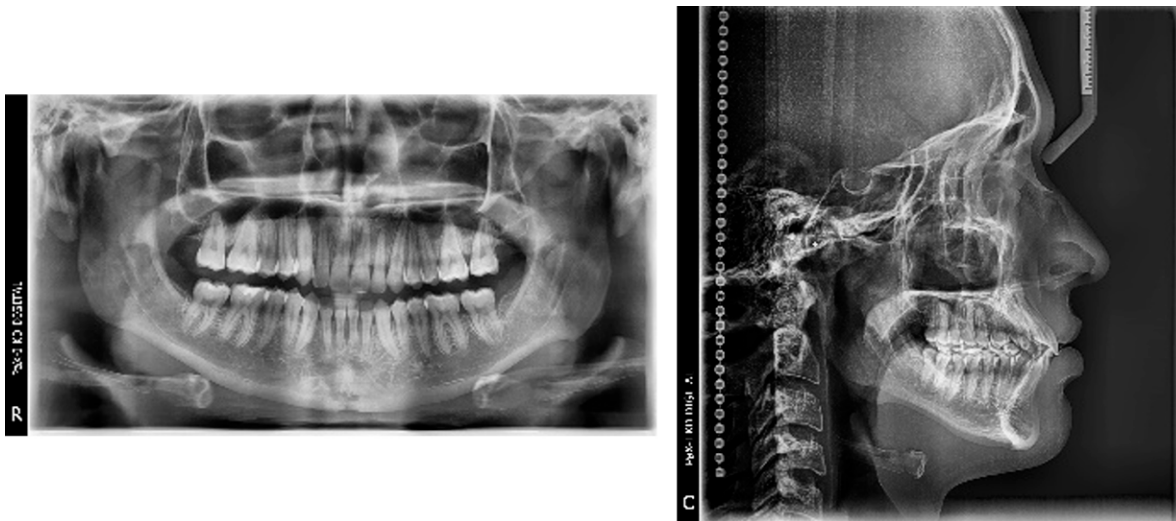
Orthopantomography and final lateral headfilm radiographs
